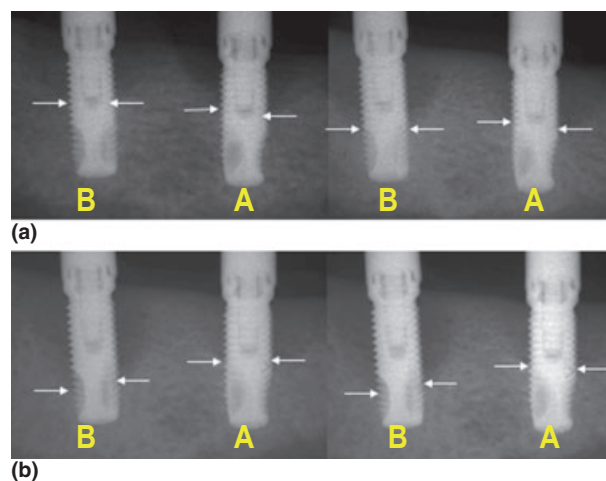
Radiographs from implant types A and B (from left) obtained at ligature removal (baseline) (a) and at biopsy (26 weeks) (b). Arrows indicate bone levels.
